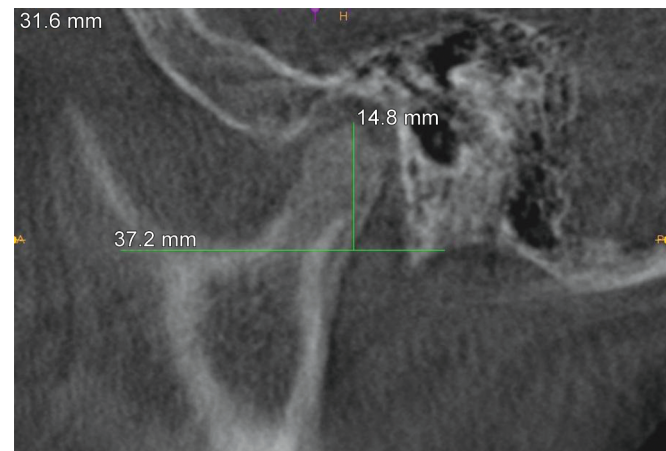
Cone-beam computed tomography (CBCT) scan of condylar height pretreatment
